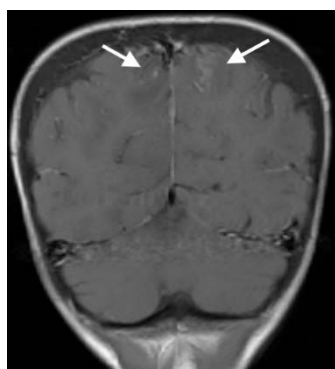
A case of atypical PRES. Contrast enhancement (arrows) in the gyral pattern at the level of bilateral parietal lobe vertex on MRI postcontrast T1-weighted imaging may develop secondary to disruption of the blood-brain barrier.
